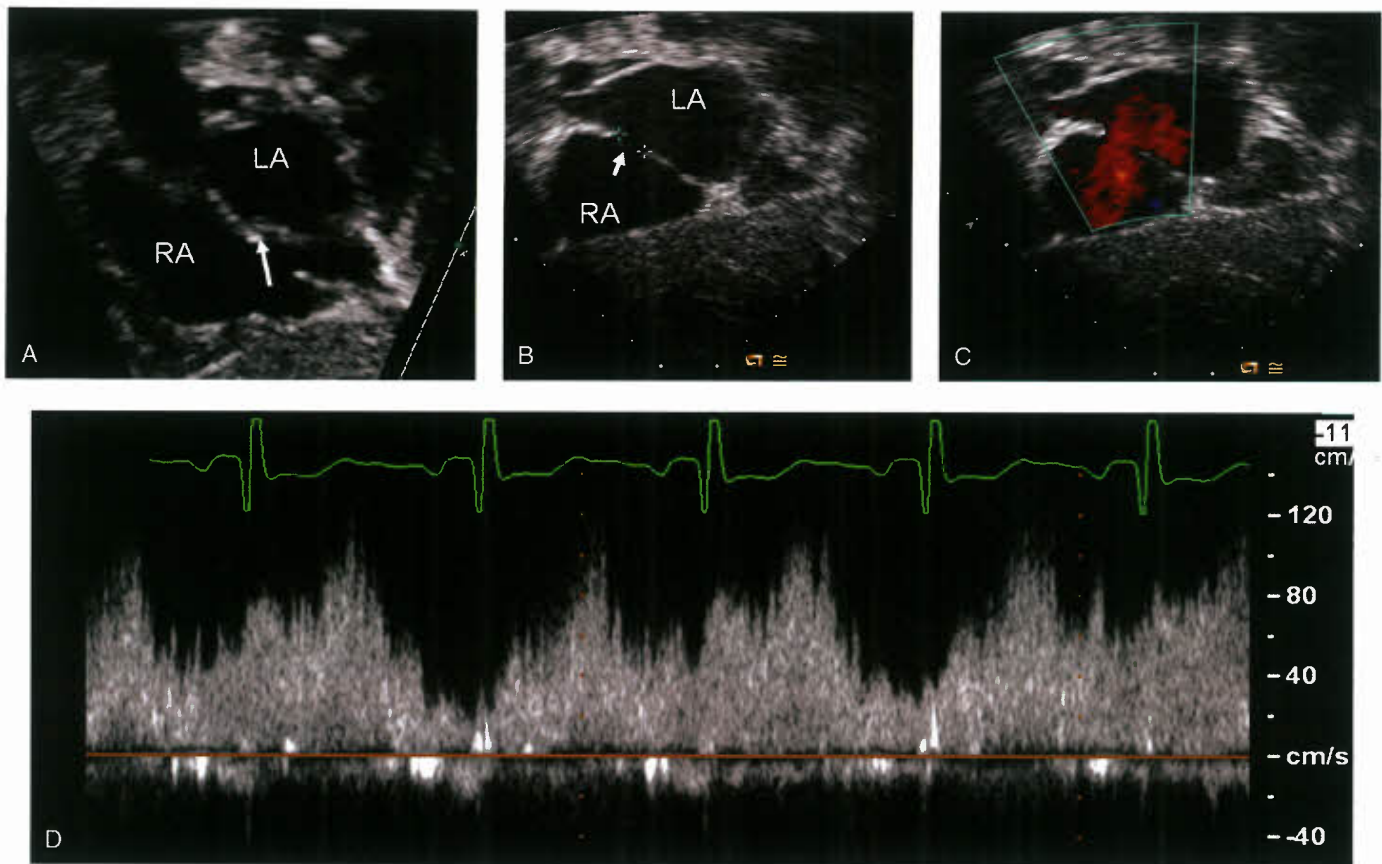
Echocardiography delineation of defects in the region of fossa ovalis. A: Subcostal sagittal view showing a PFO (*arrow*), with a flap valve noted on the left atrial side and the limbus of fossa ovalis on the right atrial side. B: Subcostal coronal view showing a large secundum ASD with well-defined rims. C: Color Doppler showing a left-to-right shunt across the ASD. D: A pulsed-wave Doppler showing a left-to-right shunt across the ASD with phasic changes. LA, left atrium; RA, right atrium.
